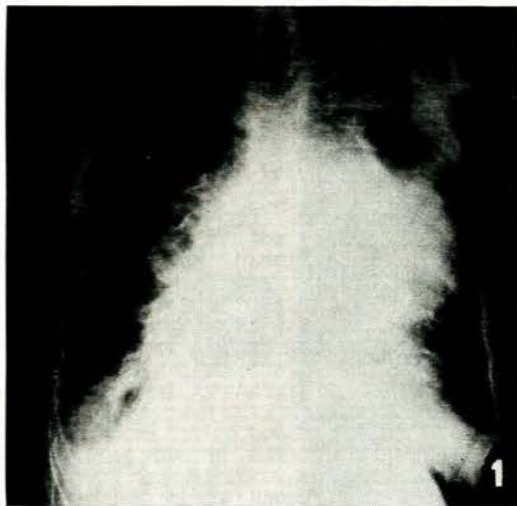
X-ray of chest (see text).
